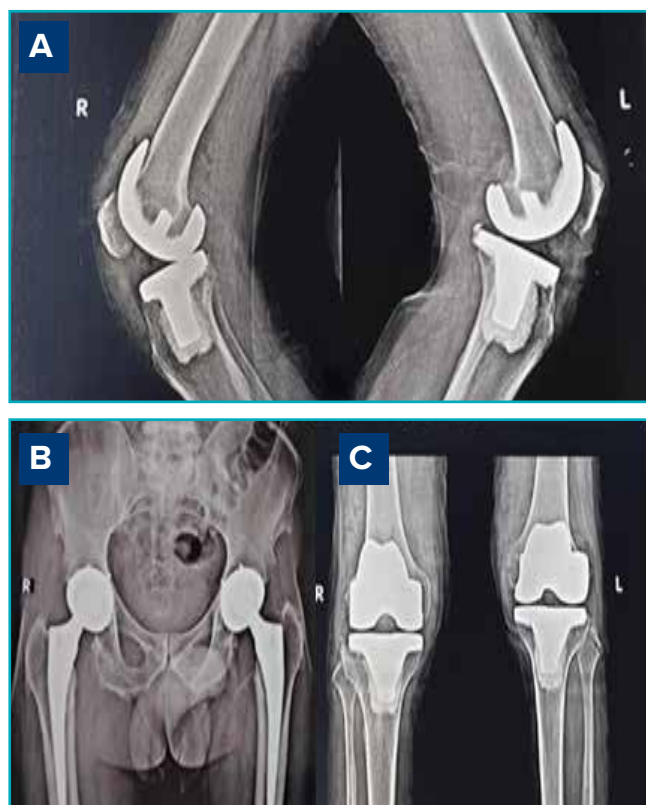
A, C. 6 months follow-up X-ray of total knee replacement lateral and anterolateral view, B. 12 months follow-up X-ray of total hip replacement anteroposterior view.
